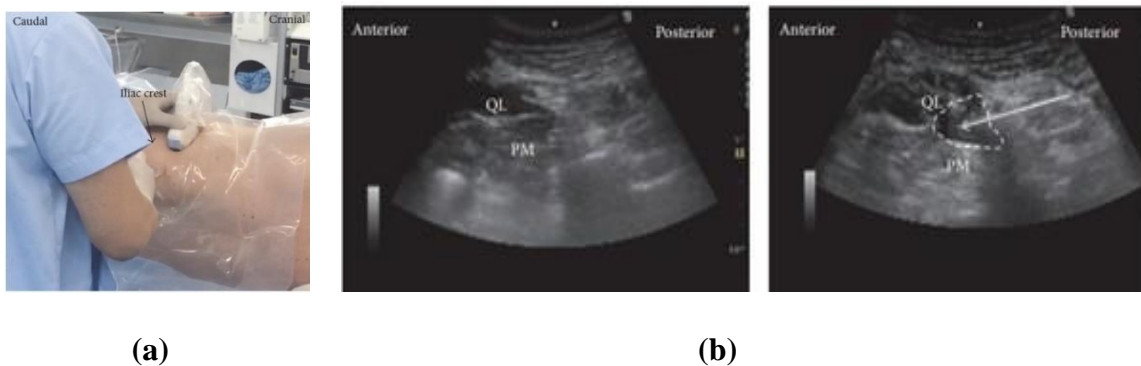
Anterior quadratus lumborum block approach: (a) probe position (b) Ultrasound images, QL: quadratus lumborum, PM: psoas muscle, white arrow: needle trajectory and white dotted line: the spread of local anesthetic (36).
